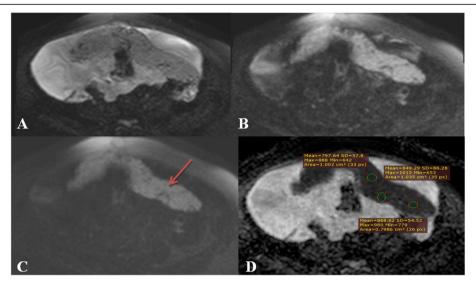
Forty-nine years old male patient, with abdominal pain and distension, a peritoneal mass was detected during abdominal ultrasound. a DWI at b 0. b DWI at b 500. c DWI at b 1000. d ADC map. The images showed a large irregular solid peritoneal mass lesion with high signal in DWI and low in ADC map, impressive of restricted diffusion with average ADC value $0.5 \pm 0.02 \times 10^{-3}$ mm²/s. Final diagnosis after pathological examination was peritoneal sarcomatosis
